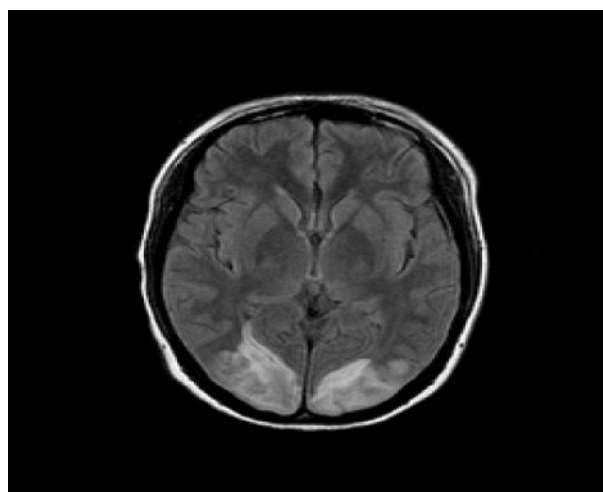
FLAIR MRI image of the patient on 23 October 2005, showing bilateral occipital lesions.
